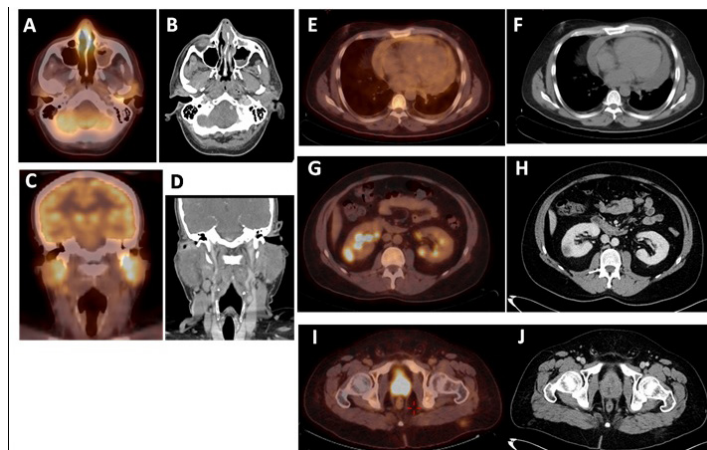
F-18 FDG PET/CT and CT head and neck, chest, abdomen, and pelvis revealed high metabolic uptake in nasal region (A) with mucosal hypertrophy on computed tomography (B), high uptake in enlarged parotids (C and D), pericardial effusion (E and F), focal hypermetabolic bilateral hypodense renal cortical lesions (G and H), and hypermetabolic enlarged prostate (I and J) [25].
